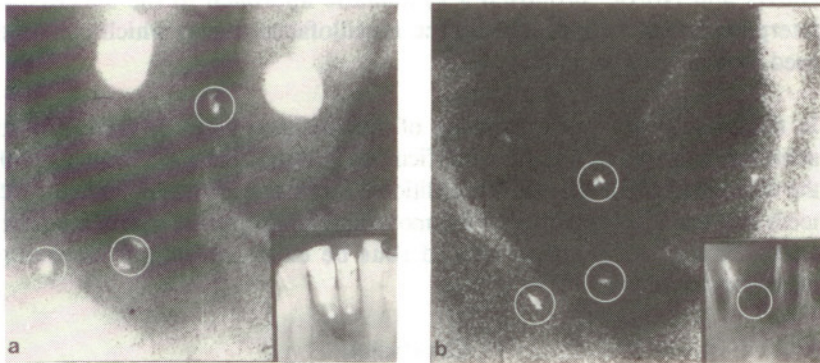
Case 2: Ante- (a) and postmortem (b) radiographs showing the configuration of the radiopaque material (circled) in the anterior mandibular incisor area (magnification x 45). Inset a: antemortem radiograph showing original size of amalgam fragments. Inset b: postmortem radiograph showing original size of amalgam fragments (circled).
